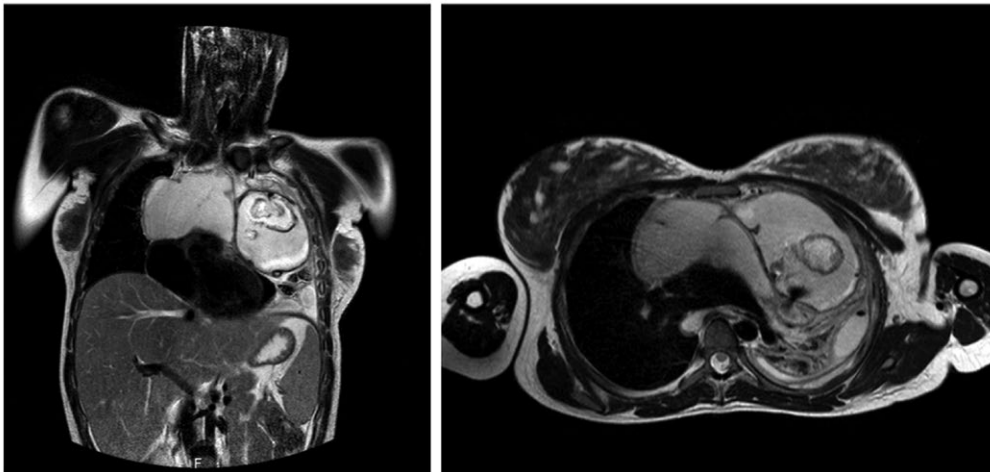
MRI revealing an anterior mediastinal mass with cystic and solid and left empyema.
